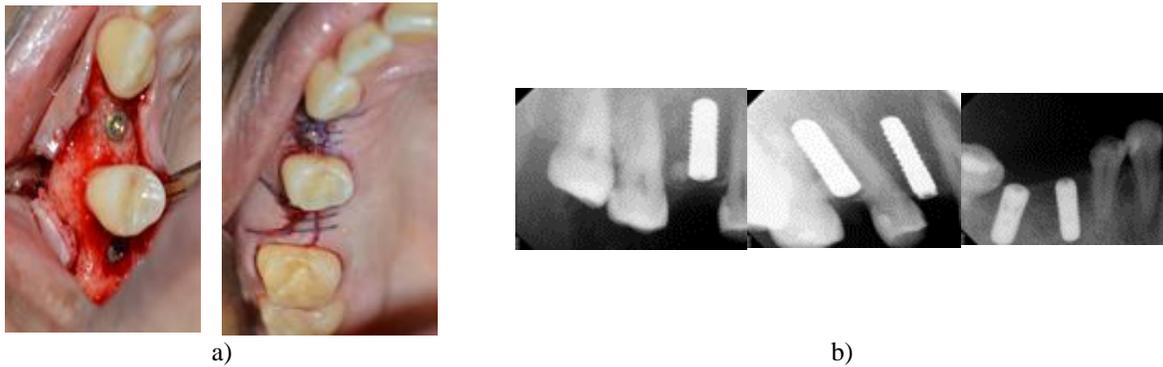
a) Implants placement #14 and 16. b) Implants fixture placement radiographs #14,16,46 and 47.
